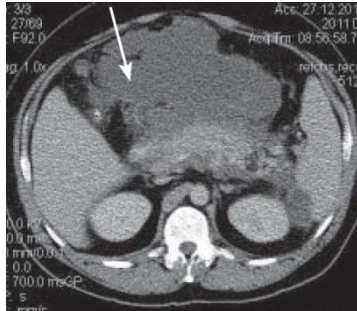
Spiral computed tomography of the abdomen. Circumscribed fluid accumulation in the projection of omental bursa and gastro-colic ligament
